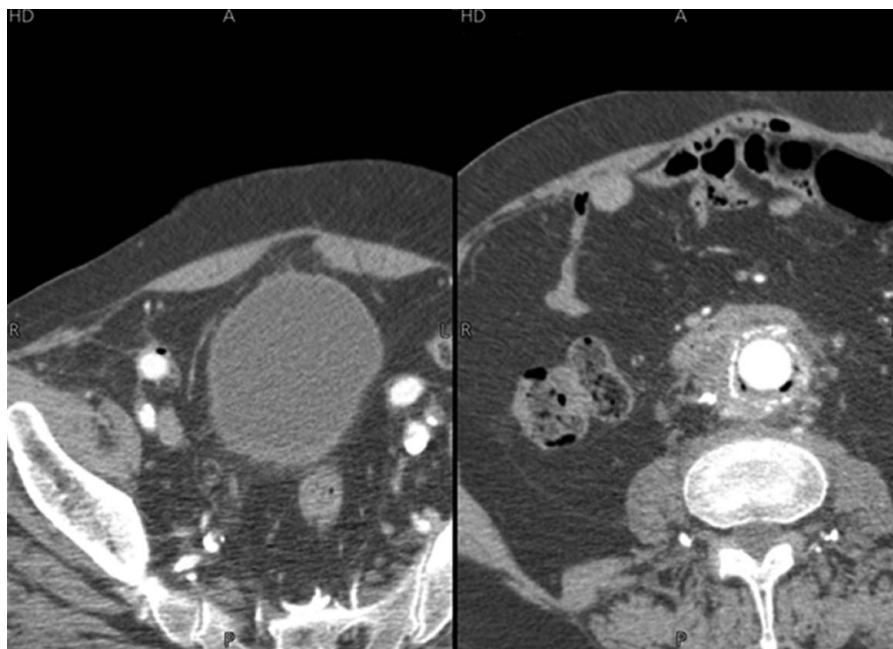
CT angiogram showing air in the wall of the aorta and air bubbles in caecum. CT, computed tomography.
